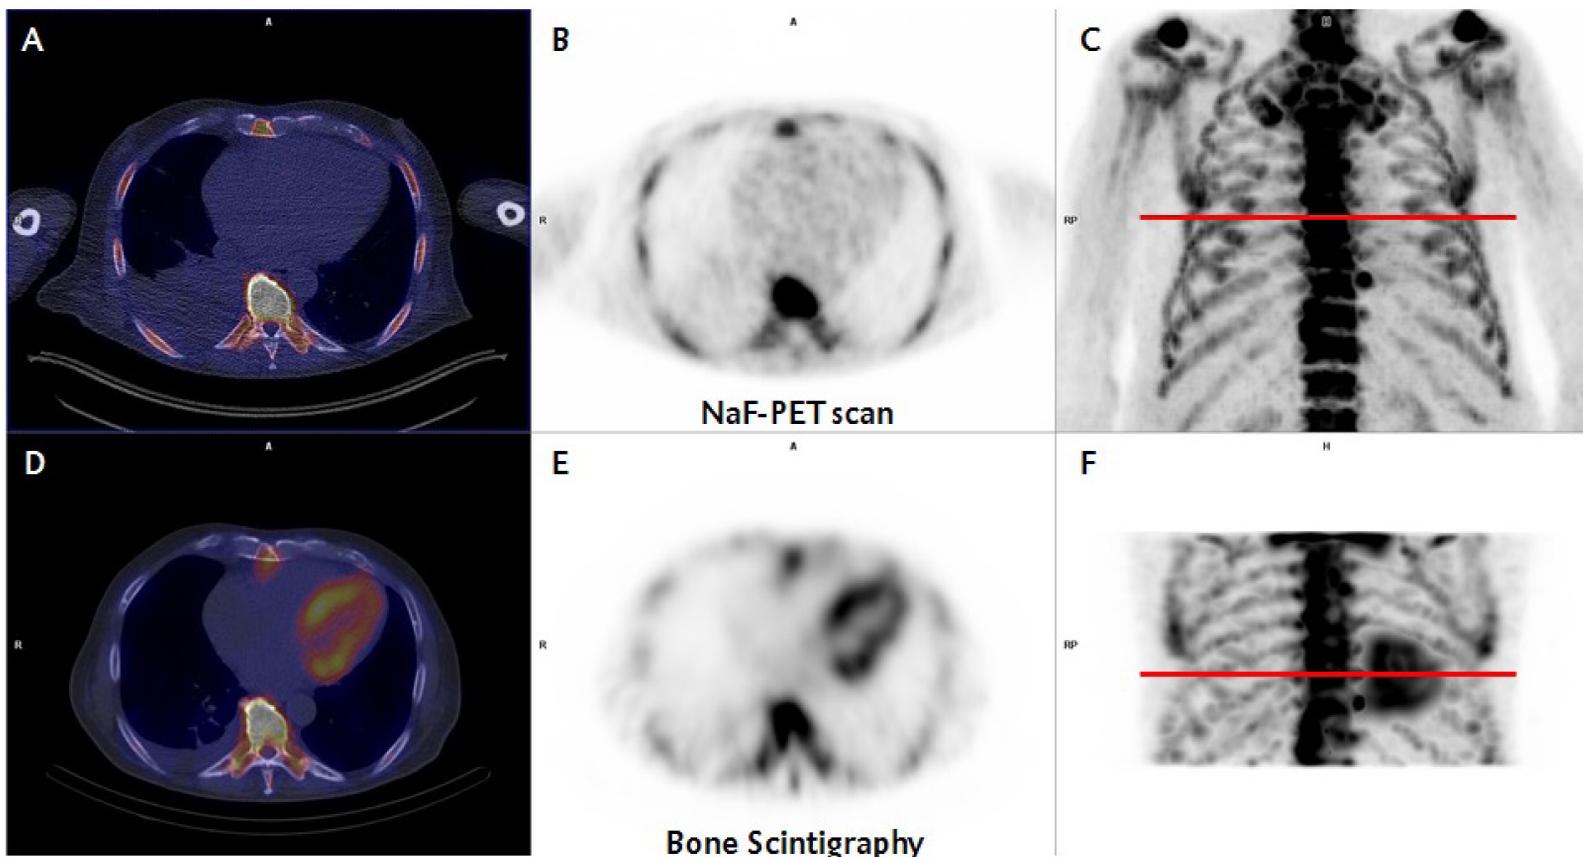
A-C. NaF-PET which shows no cardiac uptake of the tracer. D-F. SPECT/CT of a bone-scan with abundant tracer uptake (grade 3) within the myocardium of the left ventricle. Both scans were made within 3 weeks apart from each other. A, D. Fused image of NaF-PET (B, C) and bone-scan (E, F) with low-dose CT-scan. The red line in C and F is the level of the transverse plane used in A, B, D, and E.
